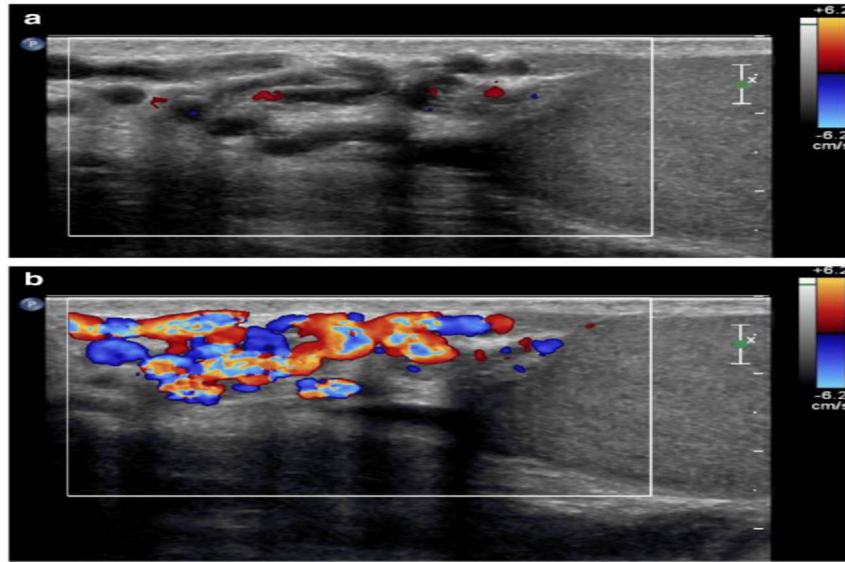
Small varicocele lying above the testis (Sarteschi grade II). Colour doppler images obtained at rest (a) and during valsalva (b) showing that reflux was detected only during Valsalva.
